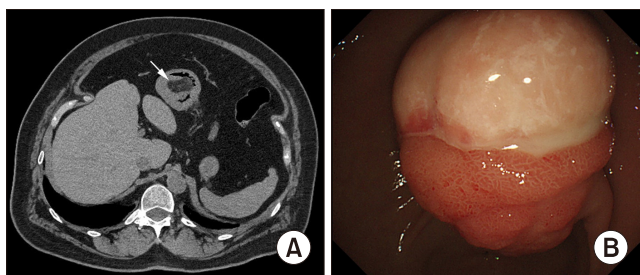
(A) CT showed a submucosal lesion in the antrum (arrow), which appeared partially solid with uniform fat density, suggestive of gastric lipoma. (B) Endoscopy disclosed a large hemisphere submucosal lesion in the gastric antrum. The tumor showed apical ulceration without active hemorrhage.
